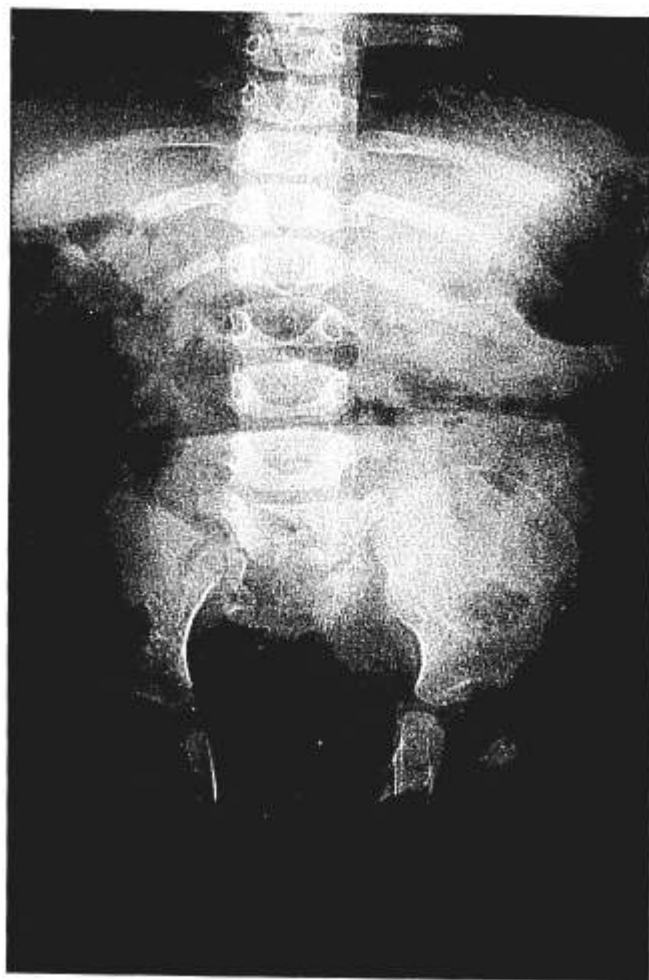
X-ray of case 1, showing sacral agenesis with sacralization of fifth lumbar vertebra.
